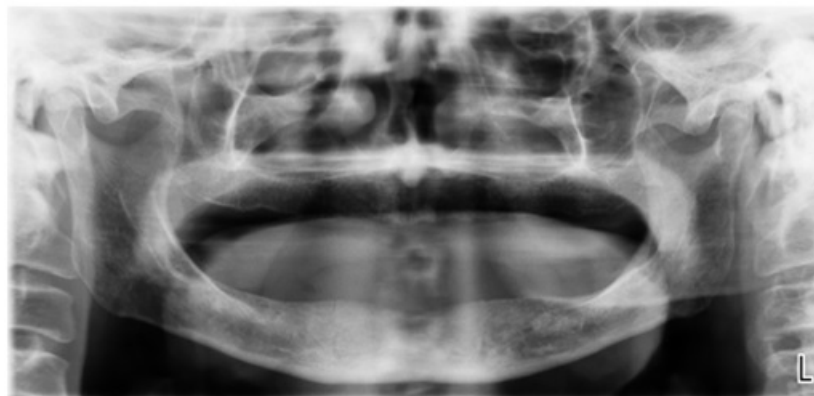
Panoramic radiography of the patient with oral squamous cell carcinoma
